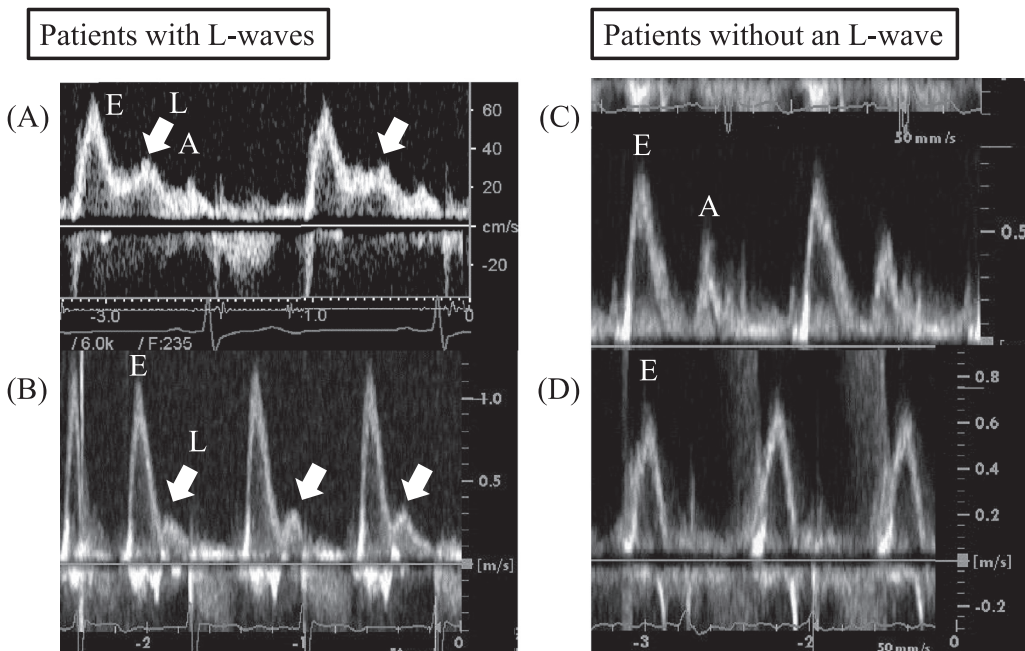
Representative echocardiographic images of pulsed Doppler imaging of mitral inflow in patients with HC with an L-wave and without an L-wave. (A, B) Mitral L-waves in a patient with sinus rhythm (A) and in a patient with atrial fibrillation (B). (C, D) A patient without a mitral L-wave and with sinus rhythm (C) and a patient without a mitral L-wave with atrial fibrillation (D). White arrows indicate an L-wave. HC, hypertrophic cardiomyopathy.
